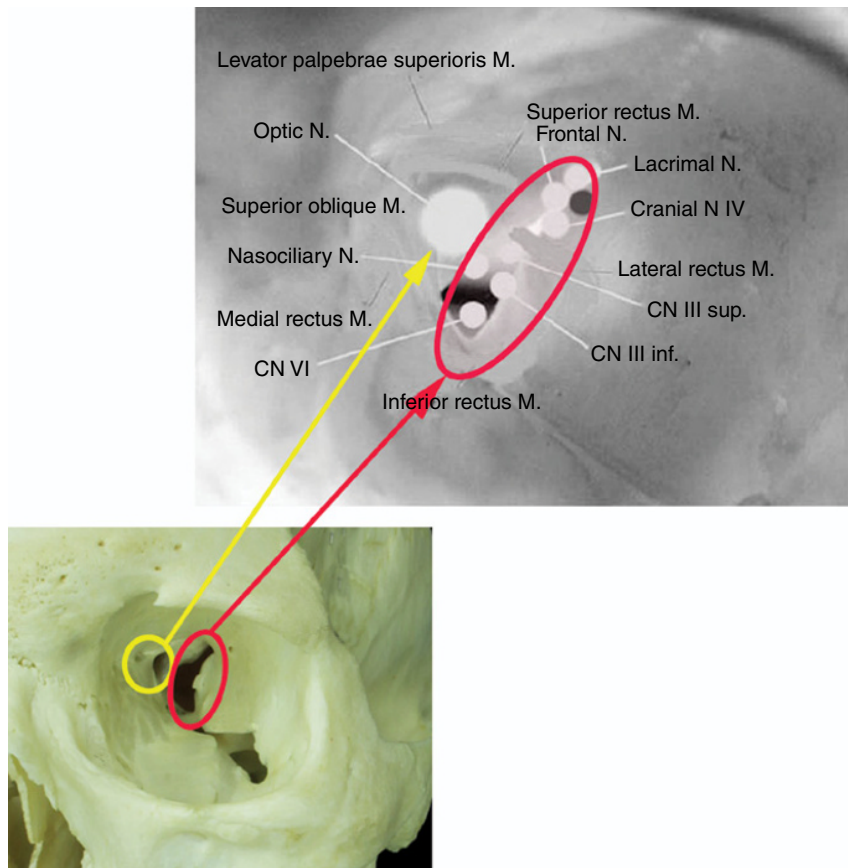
The main upper image shows an enhanced radiographic image in which the nerves entering the orbit through the superior orbital fissure and optic canal (optic nerve) are identified. The lower image shows these canals on a frontal view of the bony orbit. Main figure is reprinted with permission from Kelts (2010).
